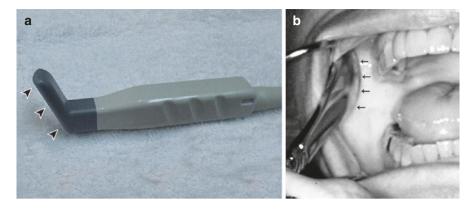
Intraoral probe and probe positioning. (a) Philips skeletal hockey-stick probe used for transoral sagittal ultrasound probe. The probe imaging aperture (arrowheads) is placed vertically between the cheek and gum of the upper maxillary arch and directed cephalad toward the external auditory canal. (b) Spatula demonstrating placement of probe aperture for intraoral imaging. The hockey-stick probe is ergonomically suboptimal but is what is currently available. Arrows delineate the edge of the spatula where the probe aperture would be located
